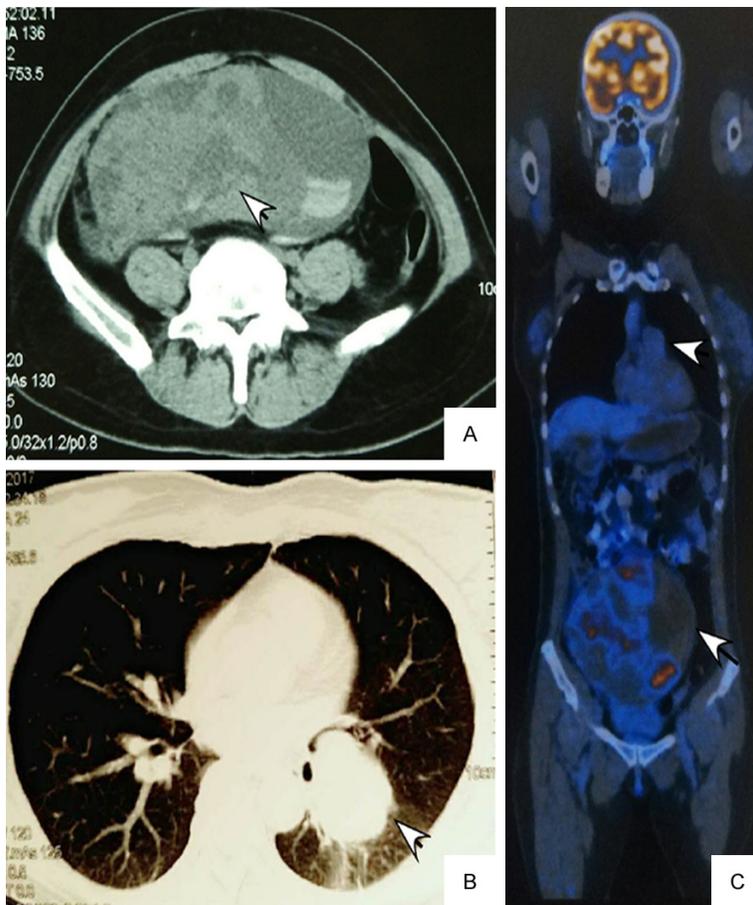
A. Abdominal computed tomography (CT) showed a giant well-defined oval mass (arrow) in the right abdomen. B. Chest CT revealed a round mass (arrow) in hilus of the left lung. C. PET-CT revealed increased FDG uptake in the abdominal mass (arrow) and the mass in hilus of the lung (arrow).
